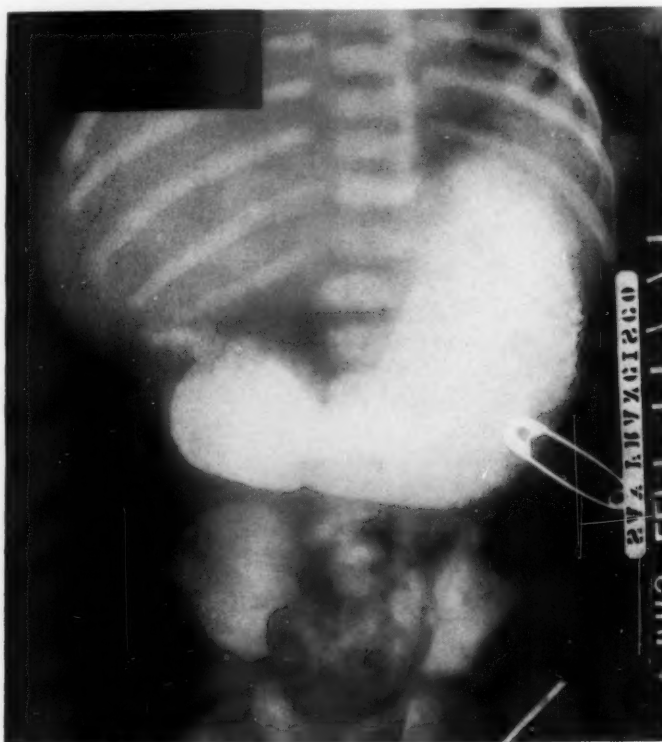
Case 1: Radiograph three hours after barium meal showing almost complete retention. A minute quantity of barium has passed into the proximal jejunum.
